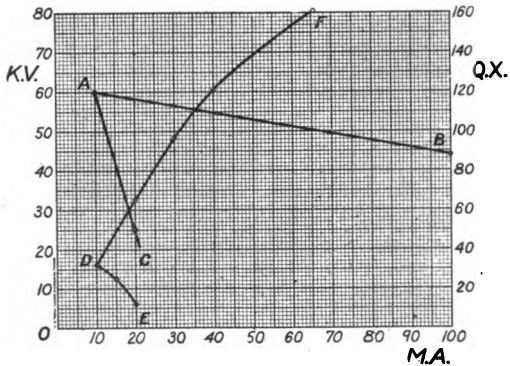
Relation of X-ray production on two types of control. AC, rheostat voltage current line. Voltage ordinates at the left. DE, corresponding X-radiation, quantity ordinates at the right. AB auto transformer chart line. DF., corresponding quantity line. Quantity in arbitrary units.
